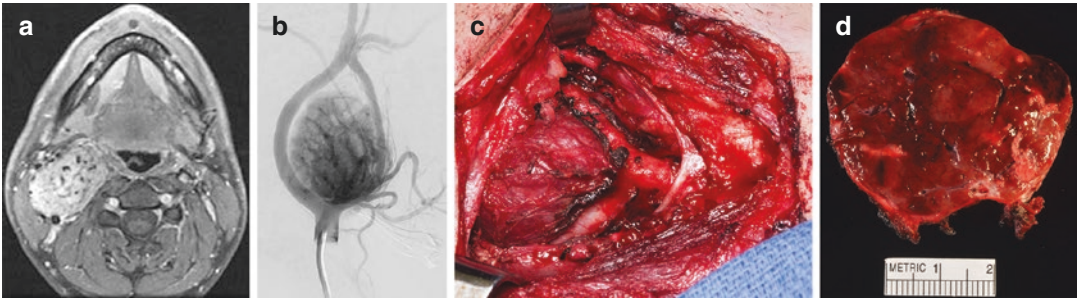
(a) T1, post-gadolinium magnetic resonance imaging study demonstrating a hypervascular mass with multiple flow voids at the level of the carotid bifurcation consistent with a carotid body paraganglioma. The internal and external carotid arteries are splayed as a result of the tumor. (b) Common carotid artery cervical angiogram demonstrates a large hypervascular carotid body paraganglioma.
